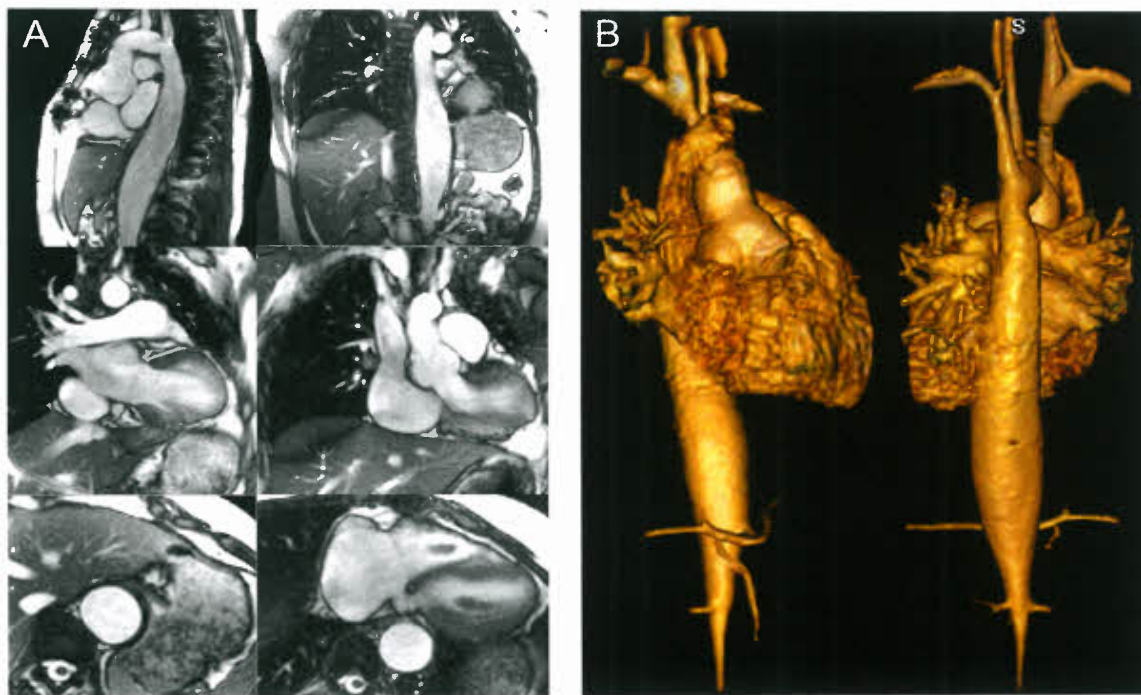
Large aneurysm of the descending aorta in a patient with connective tissue disorder who underwent replacement of the ascending aorta and transverse arch. A: SSFP cine MRI in multiple planes; B: Volume rendered reconstruction of Gd-enhanced 3-D MRA. The left panel shows an anterior view and the right panel shows a posterior view.
